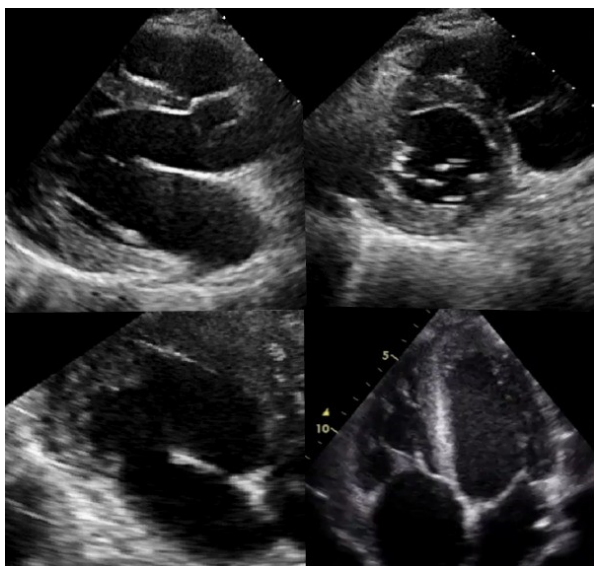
Echocardiography images of the patient
